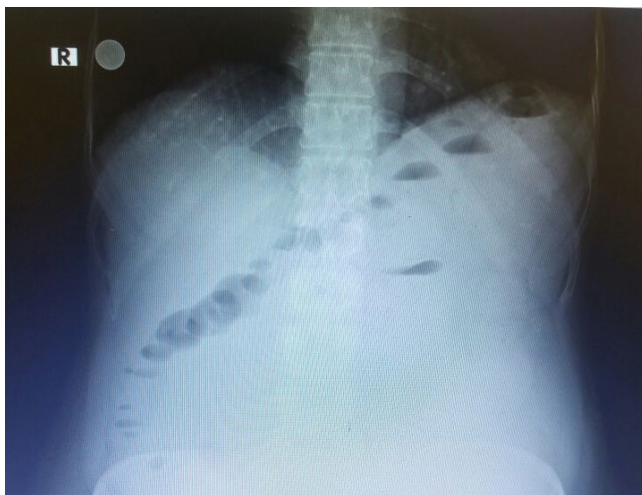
Plain abdominal X-ray: multiple air fluid level and fecal impaction air fluid level
